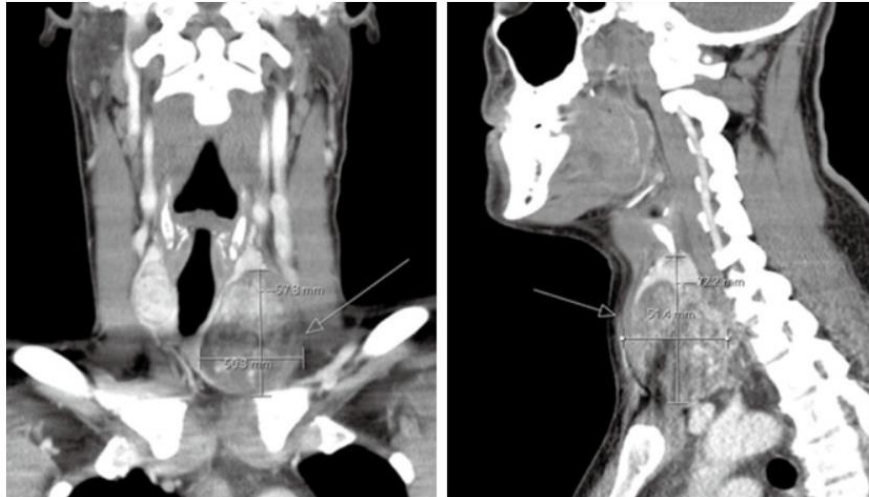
Coronal (left) and sagittal (right) CT of a 39-year-old male patient diagnosed with metastatic papillary thyroid carcinoma. Patient presents a heterogeneously enhancing thyroid nodule that is eroding through the thyroid capsule (white arrows).
